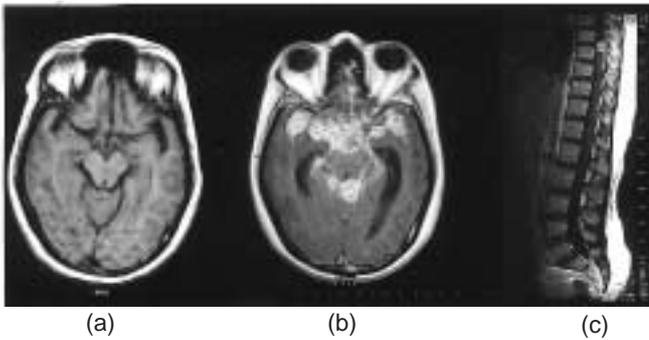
Case 3. Gadolinium-enhanced MRI head scans. (a) normal scan at presentation. (b) 2 months after starting treatment, showing paradoxical progression. (c) Gadolinium-enhanced MRI scan of the thoracolumbar spine showing an intra-dural enhancing granuloma causing cord compression at T7/8.
